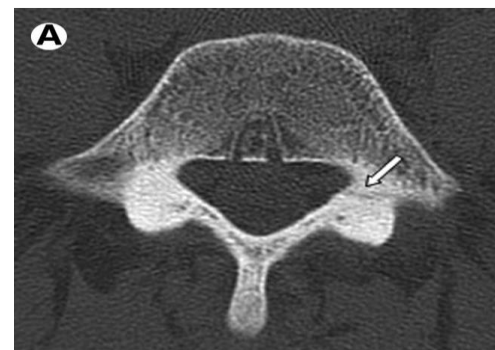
CT showing pars fracture [white arrow]
